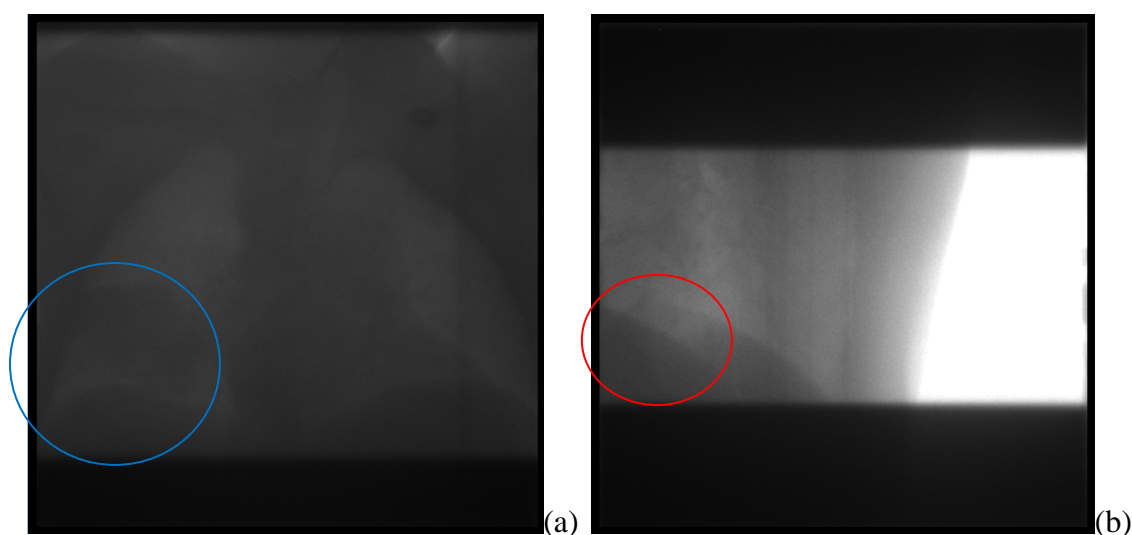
Examples of projection image of Mega-voltage cone beam CT: (a) The tumor is visible in the right lower lobe of the lung (blue ellipse). The hemi-diaphragm at the bottom of each lung is visible; (b) a lateral view shows the two hemi-diaphragms overlap with each other, making it difficult to identify diaphragm boundary in the overlapping area (red ellipse).
